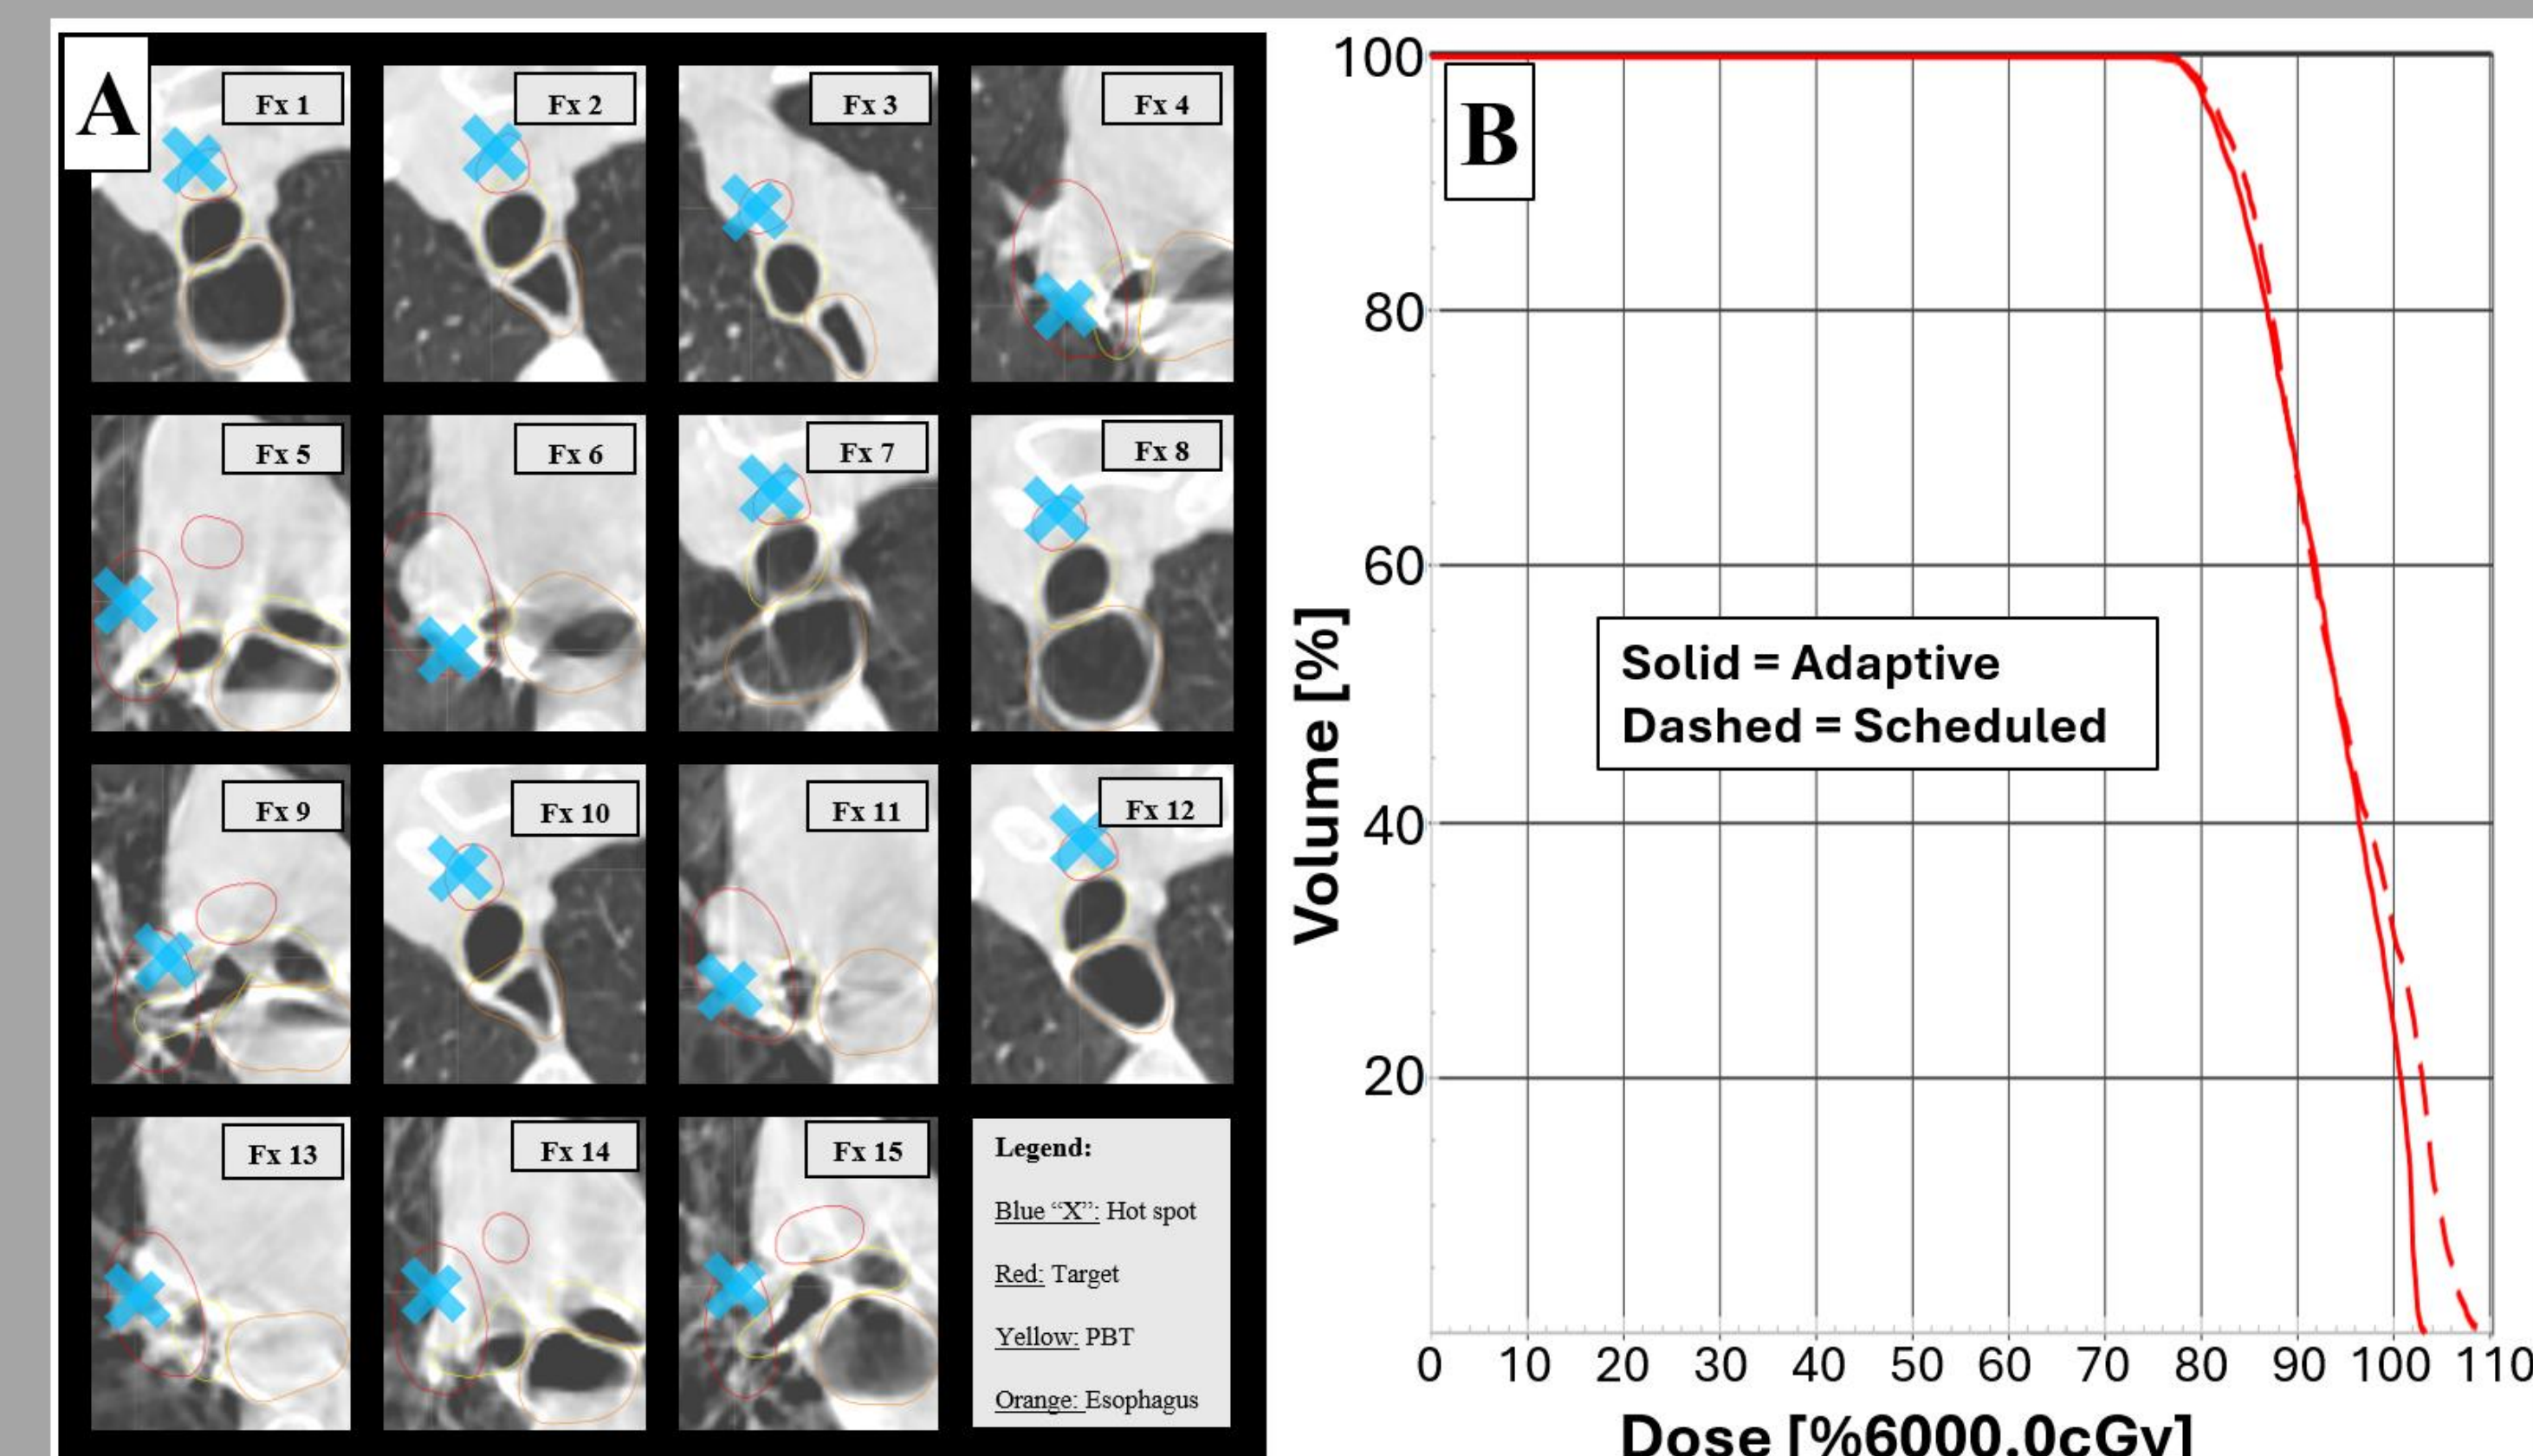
(A) Zoomed in axial slice on daily CBCT with individual adaptive fraction hot spots depicted with blue "X" demonstrating a different anatomical location daily. (B) DVH for a single patient's cumulative dose for the IGTV based on IGTV-guided rigid registrations. V6000cGy is relatively similar, whereas the maximum dose is reduced with adaptive plans, providing decreased heterogeneity.
